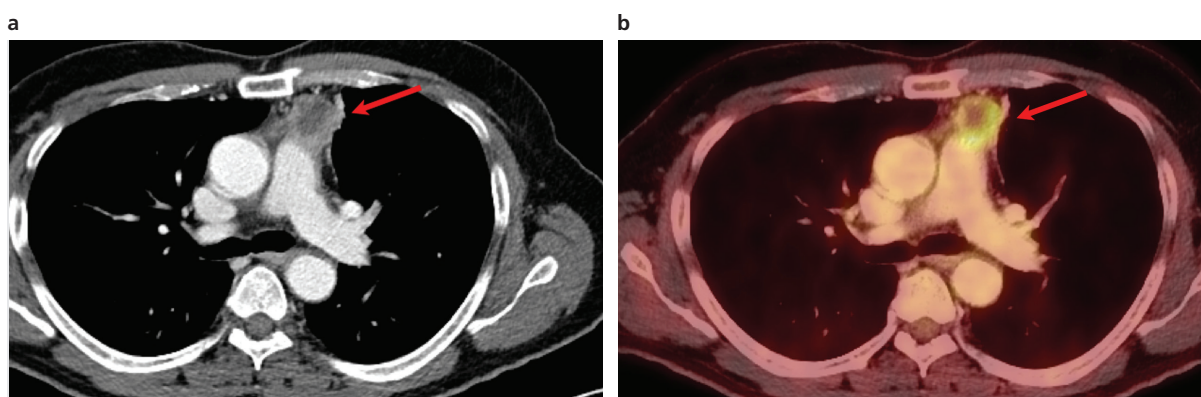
Thymic carcinoma. Sixty-six year-old man. Axial contrast-enhanced CT image (A) shows a multilobulated prevascular mass with a solid peripheral contrast-enhancing component and a non-enhancing center compatible with necrosis. No cleavage plane with the pulmonary artery. PET-CT fusion imaging (B) shows high radiotracer uptake in the solid portion of the lesion (SUV_{max} : 17.5).
